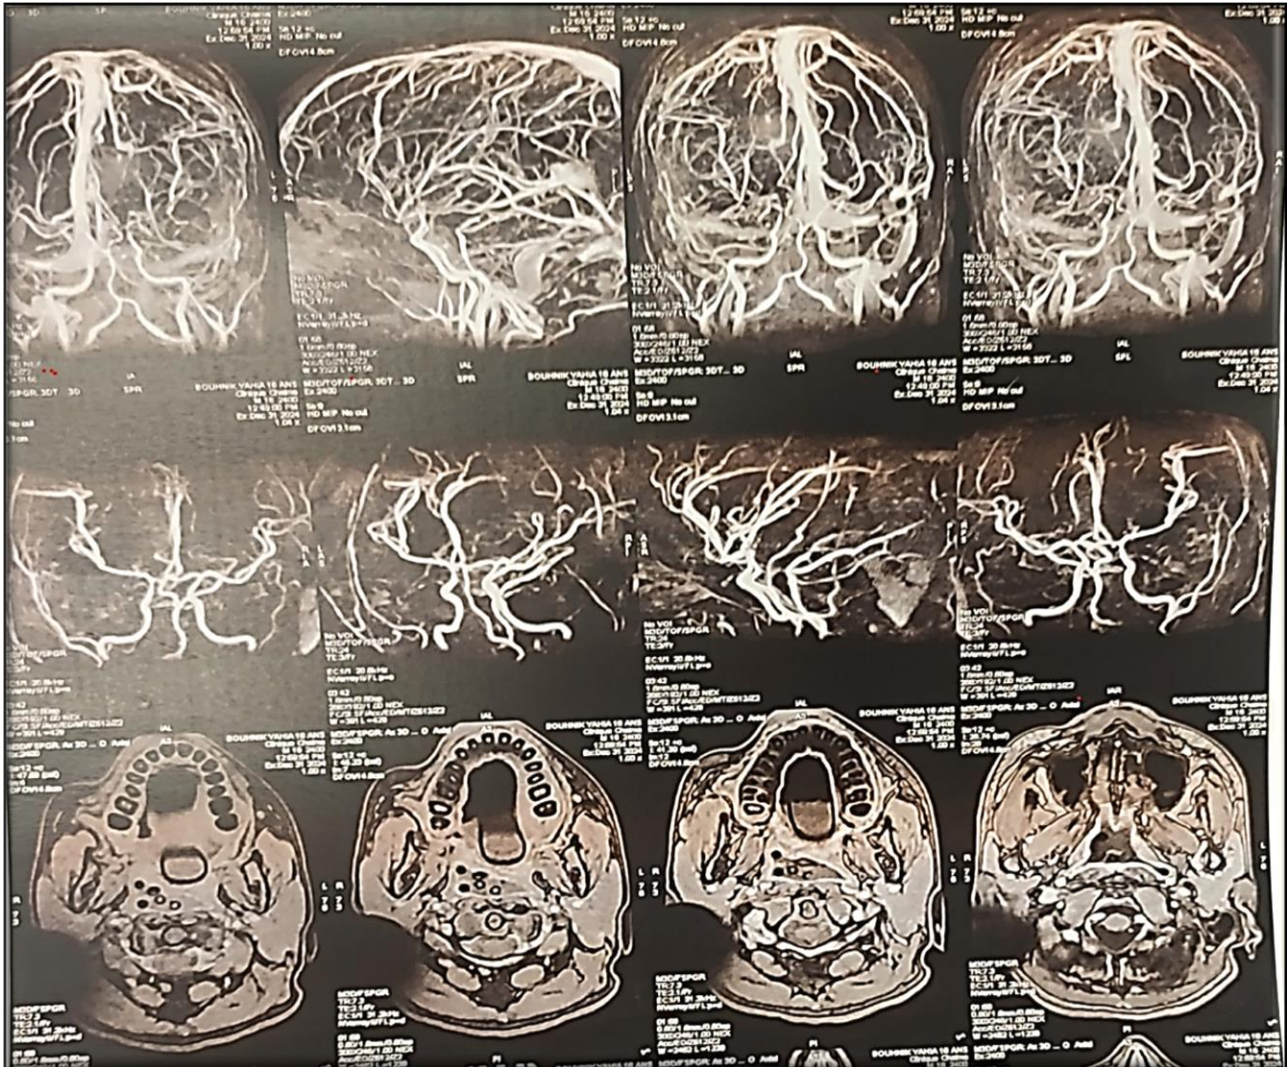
MRI results showing an extended transverse thrombosis to the sigmoid sinus
